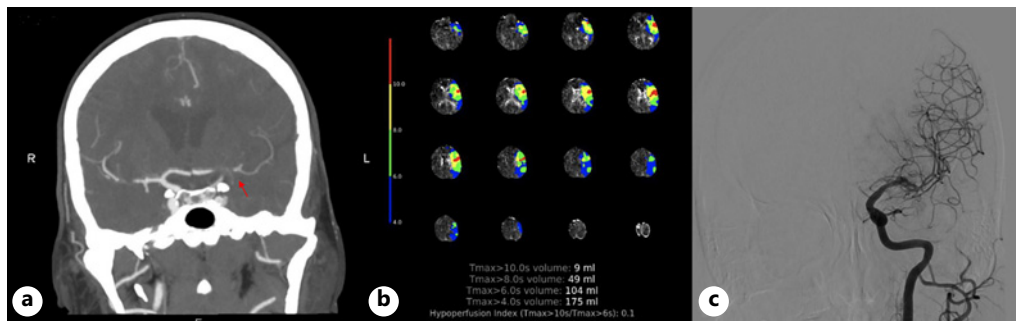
a CT angiography: severe stenosis in the A1 tract of the left ACA and occlusion of the M1 tract of the left MCA. b CT perfusion: large area of ischemic penumbra in the territory of the left MCA. c Angiography: complete recanalization after intracranial stenting from the distal carotid siphon to the M1 segment of the left MCA. ACA, anterior cerebral artery.
